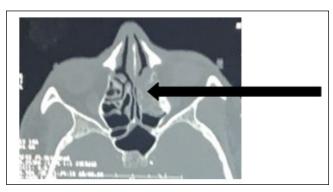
Axial Cut of CT Scan: Mass Seen in Left
